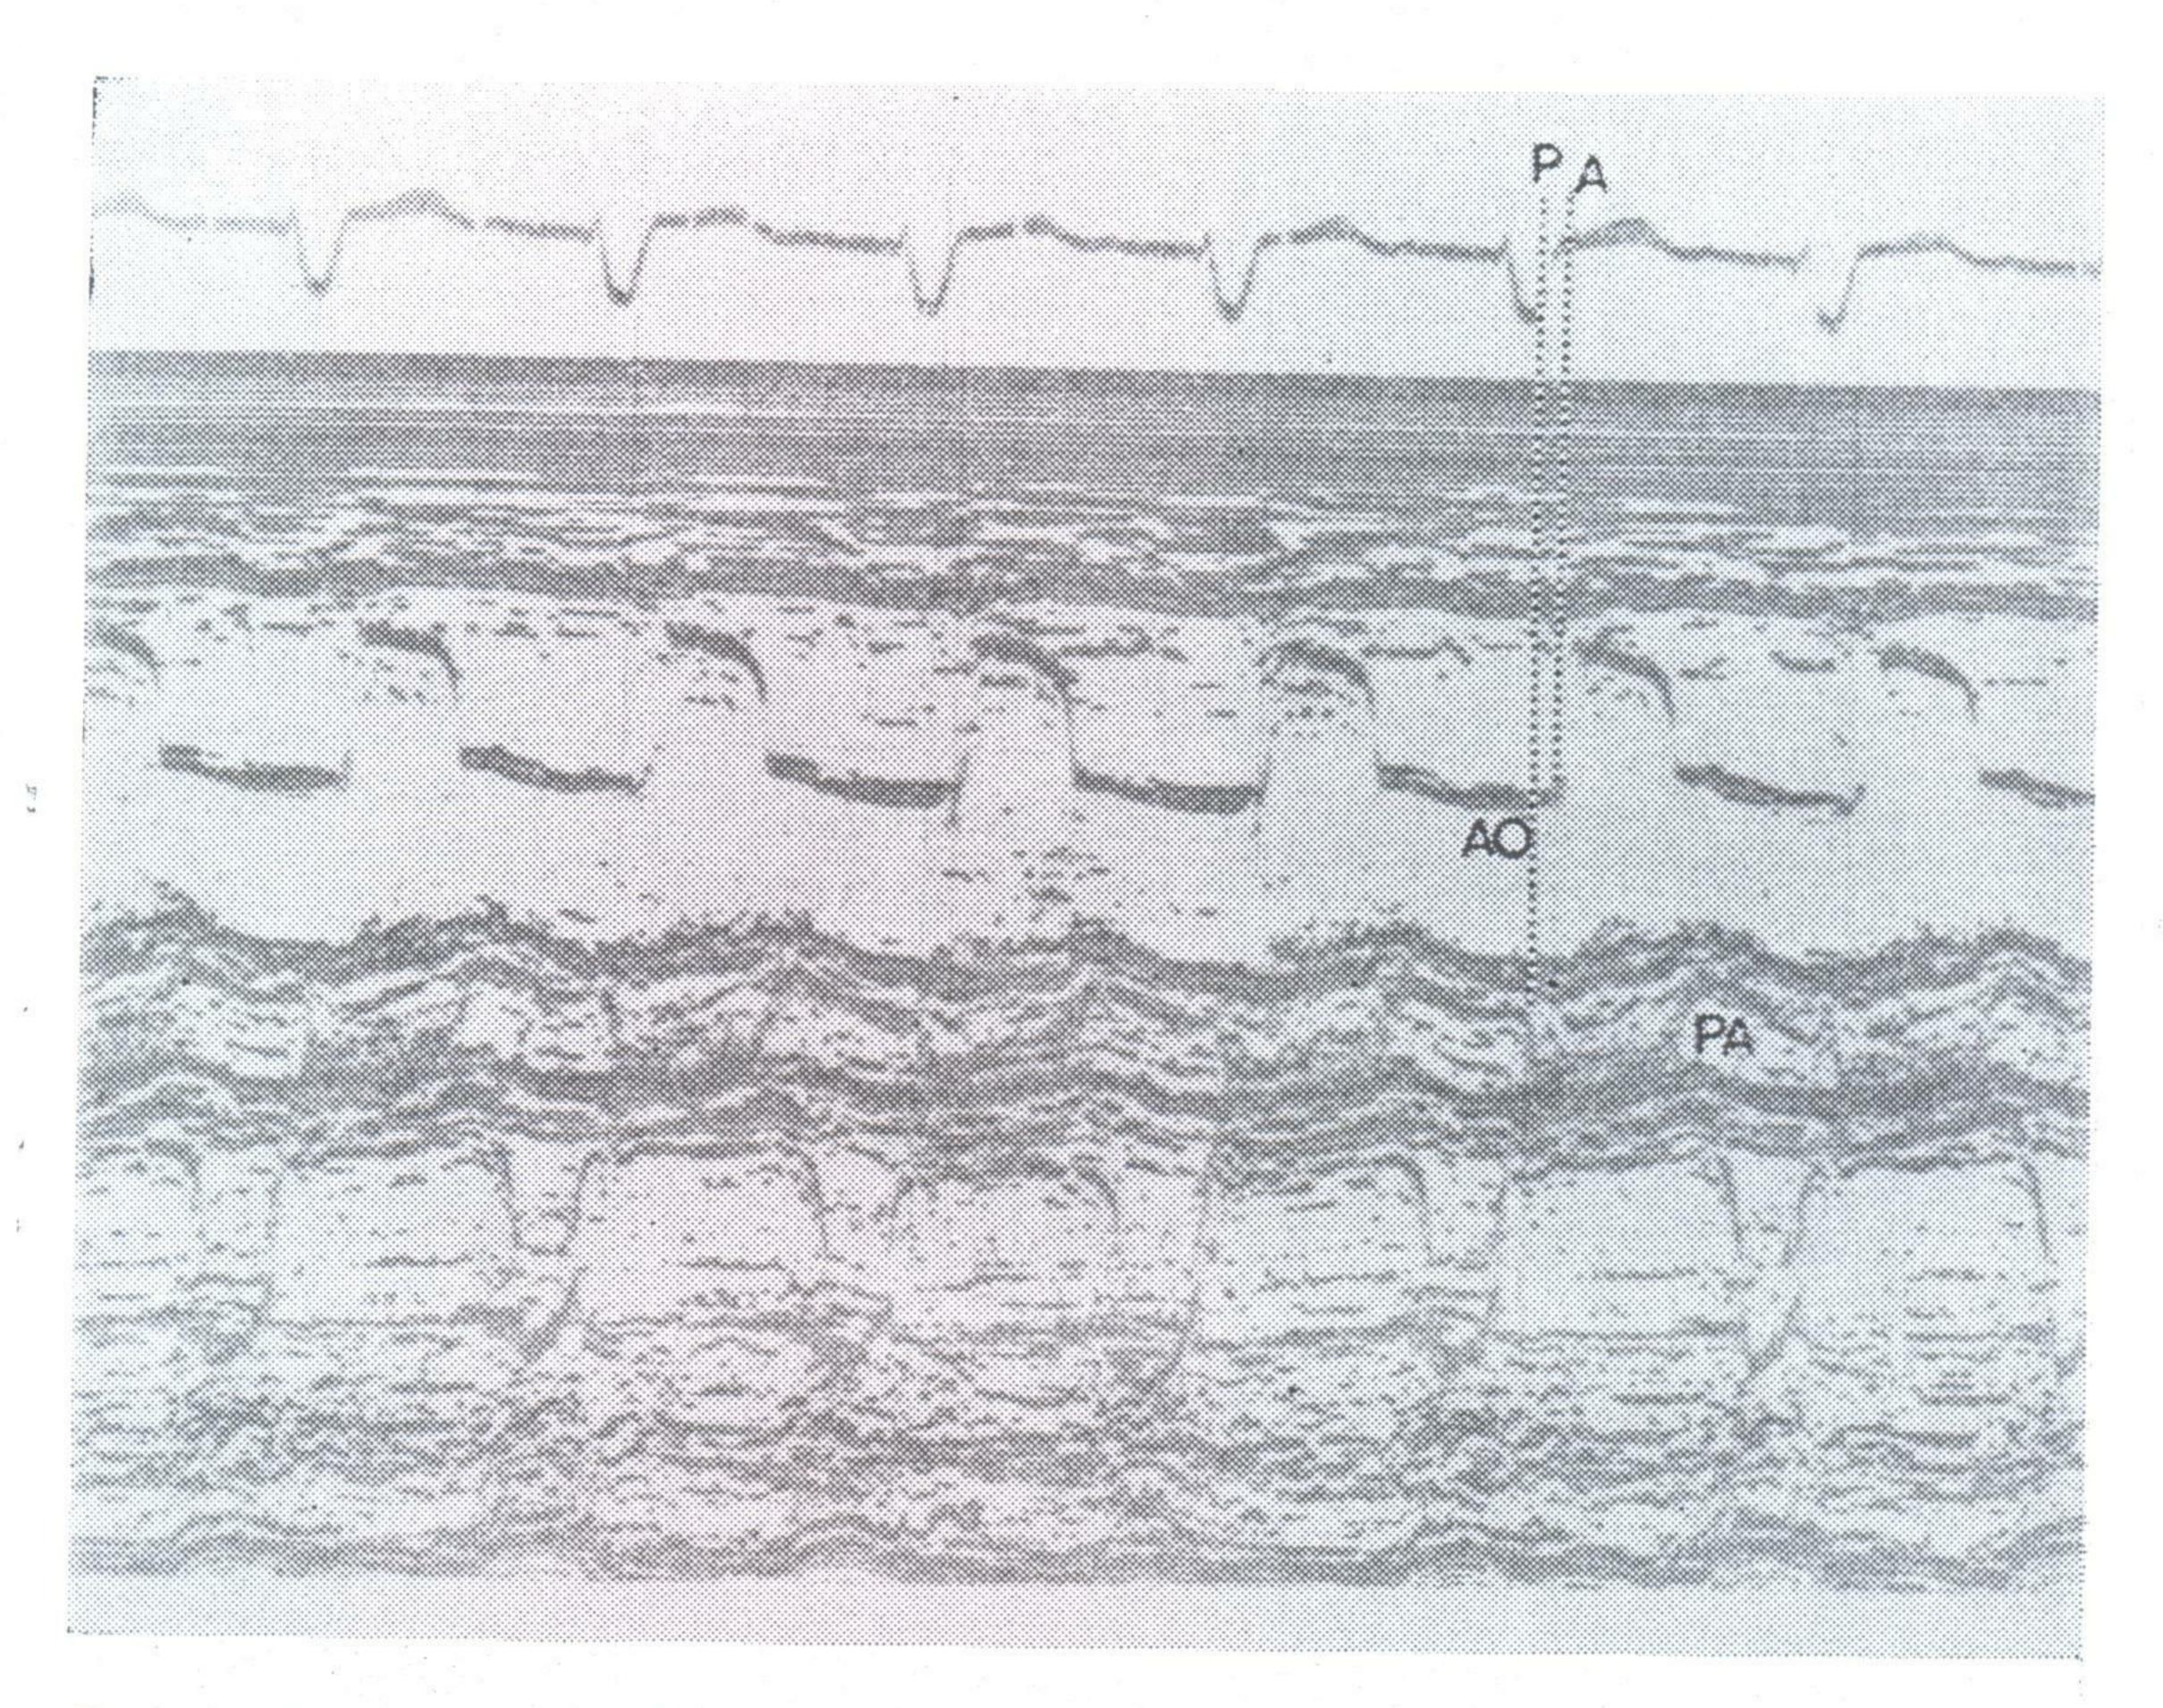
Echocardiogram in a patient with Complete transposition of the great arteries. Both great vessels are imaged with a large anterior aorta (AO) recognised by delayed opening of its Semilunar valves (Line A) compared to posterior pulmonary artery (PA) with early opening of its Semilunar valve (Line P) Note the interval between the openings of the two semilunar valves is shown by the black lines. (Line P is drawn at the opening of the posterior pulmonary artery valve which opens earlier than Aortic valve. A-line is drawn at the opening point of the anterior aortic valve, which opens later than the pulmonic valve).
